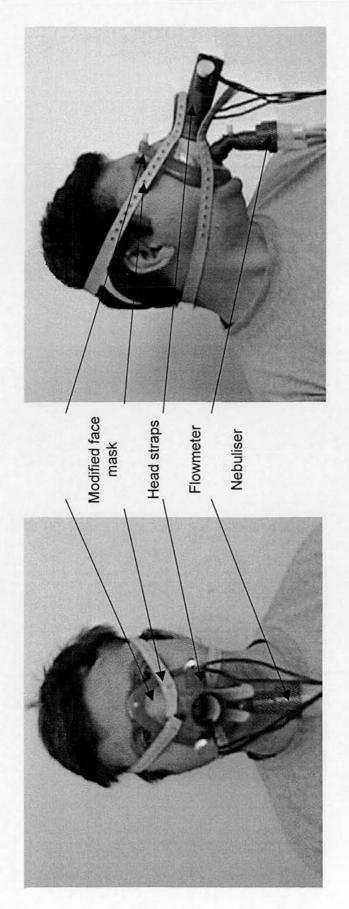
Photographs of the modified face mask used for tidal breathing flow data recording along with attached sidestream nebuliser and ultrasonic flowmeter.
